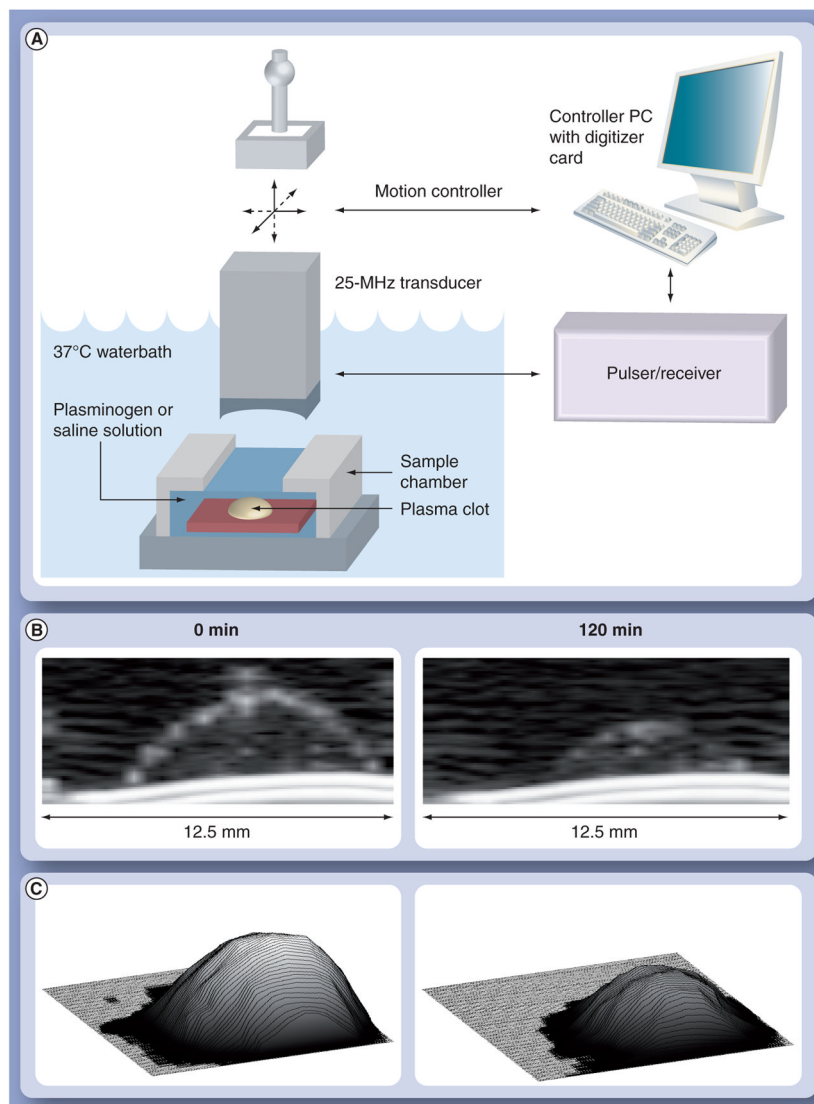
Clot digestion monitored with ultrasound
